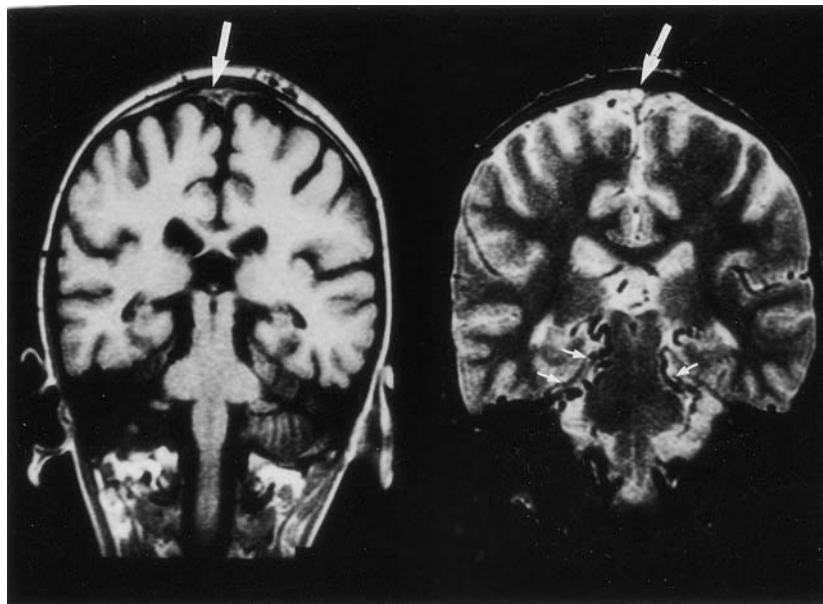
T₁- (left) and T₂- (right) weighted coronal MR images demonstrating absence of signal void in the superior sagittal sinus with iso- and hyperintensity, respectively (large arrows). Also note the increased vascular structures around the brainstem, at the tentorium (Fig. 2, right) possibly representing collateral flow due to sinus rectus involvement (small arrows).
